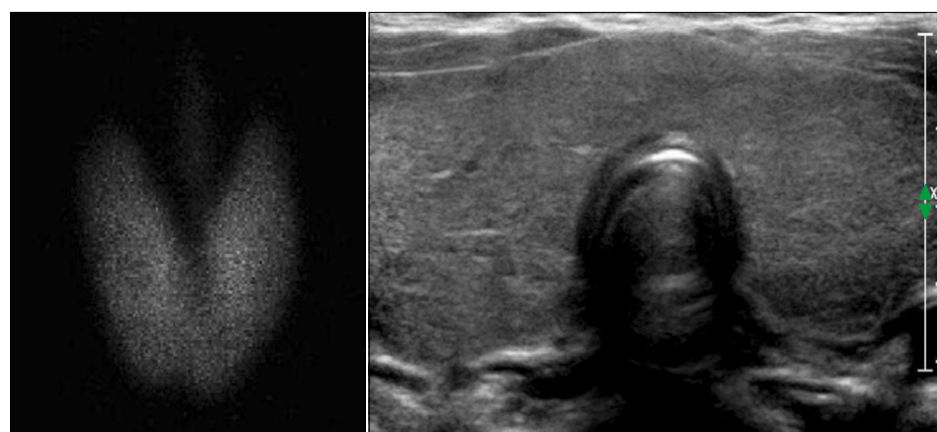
Initial thyroid examination at 8.2 years of age, shows diffuse enlargement with increased uptake in the ^{99m}Tc scan (left) and diffuse thyroid enlargement with heterogeneous echogenicity in ultrasonography (right).
